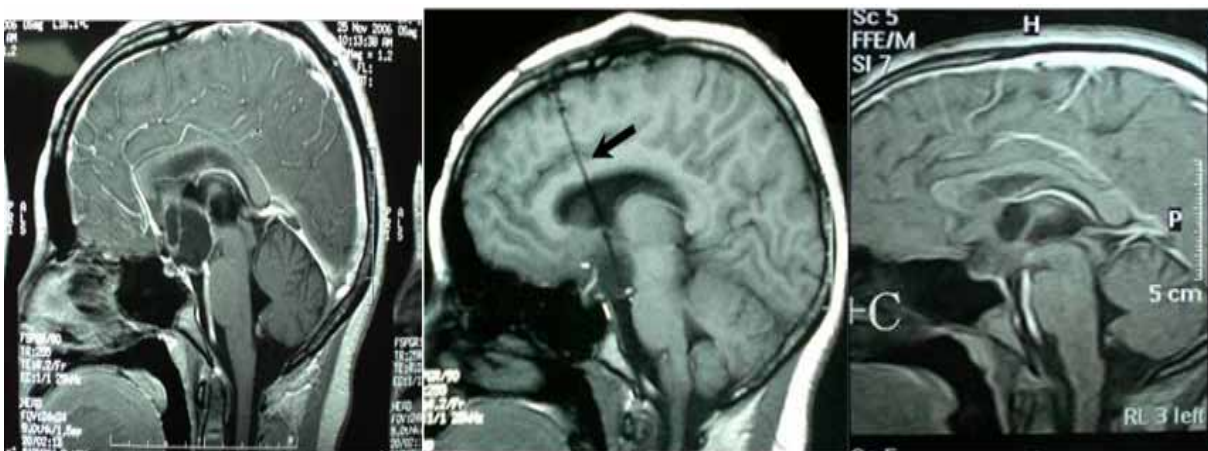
Sagittal gadolinium enhanced MRI obtained in a 15 years-old boy who underwent previous craniotomy and partial excision of a craniopharyngioma. A: a recurrent mixed tumor with the solid part extending into the supra- and retro-sellar region. Following ORS placement and RT, the cyst required infrequent aspiration over a period of 3 months followed by spontaneous cyst regression. B: sagittal and C: coronal cuts performed 26 months following ORS placement showing significant cyst involution and marked regression of the solid part.
